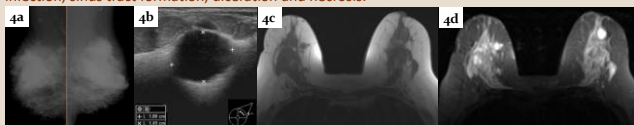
Paraffin injection in 77/F. (a) Bilateral breast MLO mammogram shows high density lobulated masses in both breasts. (b) Ultrasound shows cystic lesions. (c) T1W TSE (d) T2W TSE MRI show multiple T1W hypointense, T2W hyperintense fluid collections. Signal characteristics can vary depending on the degree of fibrosis and solidification.
